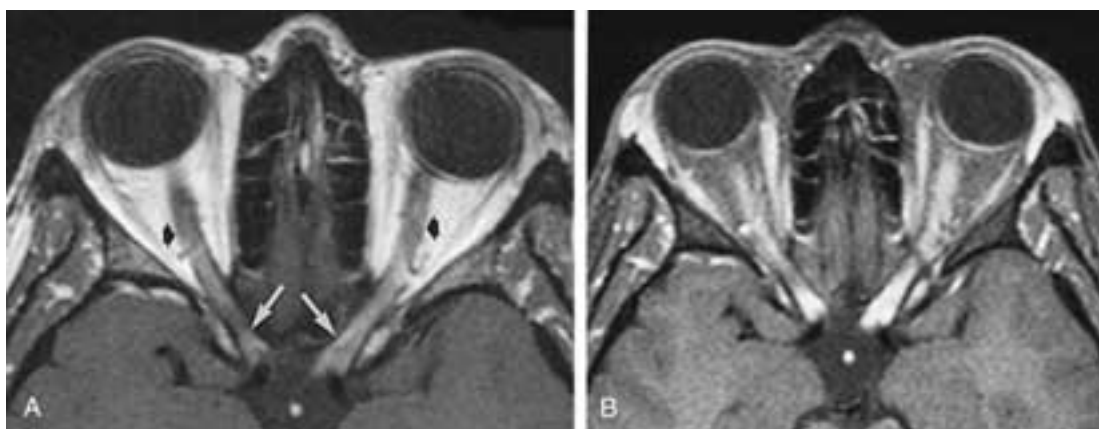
Optic neuritis. (A) Enhanced axial T1-weighted (600/18, TR/TE) and (B) enhanced axial fat-suppression T1-weighted (500/15, TR/TE) MR scans showing marked enhancement of intraorbital (*black arrows*) and intracanalicular segments (*white arrows*) of optic nerves. Biopsy revealed a demyelinating process. (From Mafee MF et al. Optic nerve sheath meningiomas: role of MR imaging. *Radiol Clin North Am* 1999;37:37–58.)
